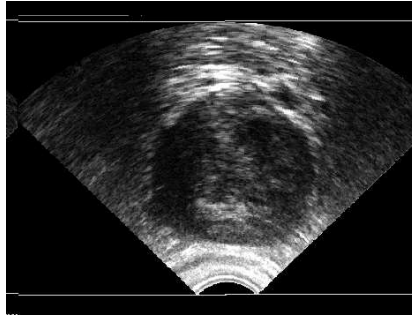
Transrectal ultrasound image
